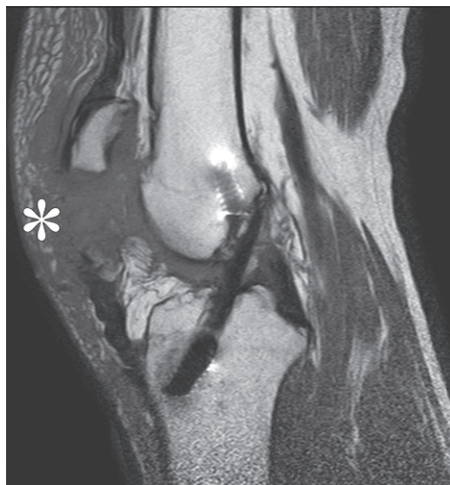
Patellar fracture after ACL reconstruction in a 34-year-old man. Sagittal PD-weighted MR image obtained after a fall shows a complete transverse fracture of the midpatella. The graft had been harvested from the inner thirds of the patella, patellar tendon, and tibial tuberosity. There is a large amount of prepatellar swelling (*) and relatively little effusion, as displaced patellar fractures allow joint fluid to exit the capsule and accumulate in the prepatellar soft tissues.
